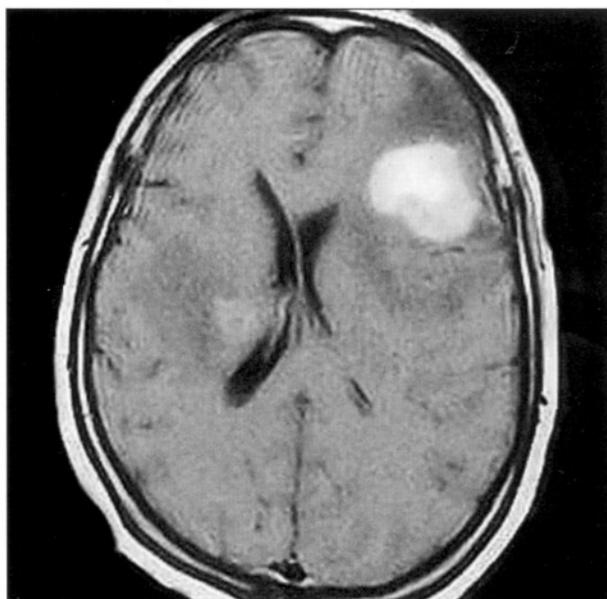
Preoperative MR imaging of the patient.
